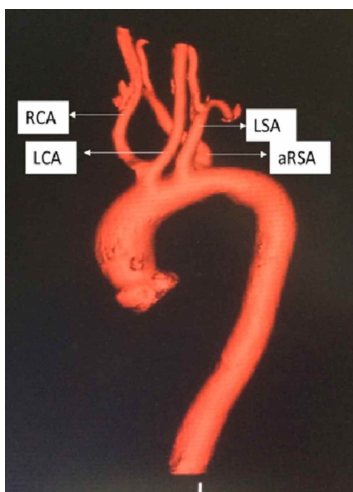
This aberrant anatomy was clearly visible in computed tomography images reconstructed 3-dimensionally using a volume-rendering technique. Truncus bicaroticus arises as the first branch of the aortic arch, the right and left carotid arteries originate from truncus bicaroticus. Left subclavian artery (LSA) arises as the second branch of the aortic arch. ARSA arises at the distal end of the aortic arch from the right side.
